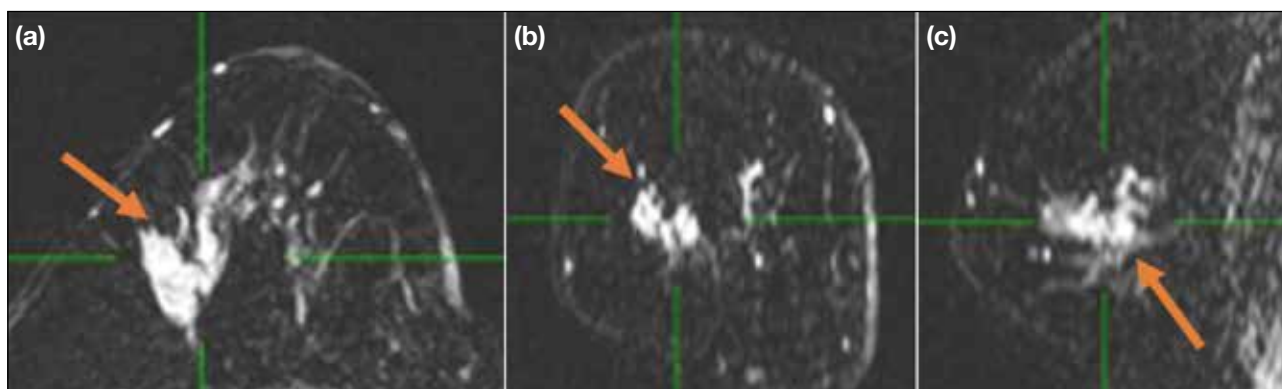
A 60-year-old woman with biopsy-proven high-grade ductal carcinoma in situ in the right breast, manifesting as clumped non-mass enhancement in a segmental distribution on magnetic resonance imaging (arrows). (a) Axial post-contrast T1-weighted image with subtraction. Reformatted coronal (b) and sagittal (c) post-contrast T1-weighted images with subtraction.
